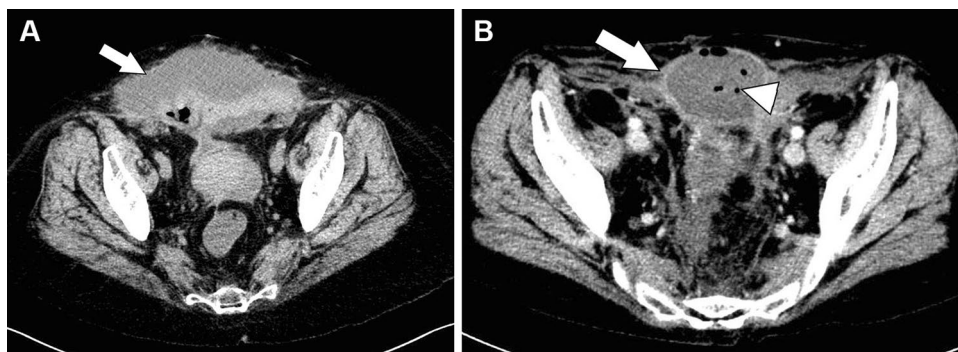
Image from axial noncontrast CT through the pelvis in a patient who underwent IIT demonstrates expected bulging along the anterior abdominal wall due to skin-only closure (a). There is non-organized fluid (arrow) along the transplant graft, which is a normal postoperative finding. Image from axial contrast-enhanced CT through the pelvis in a patient who underwent IIT demonstrates a
